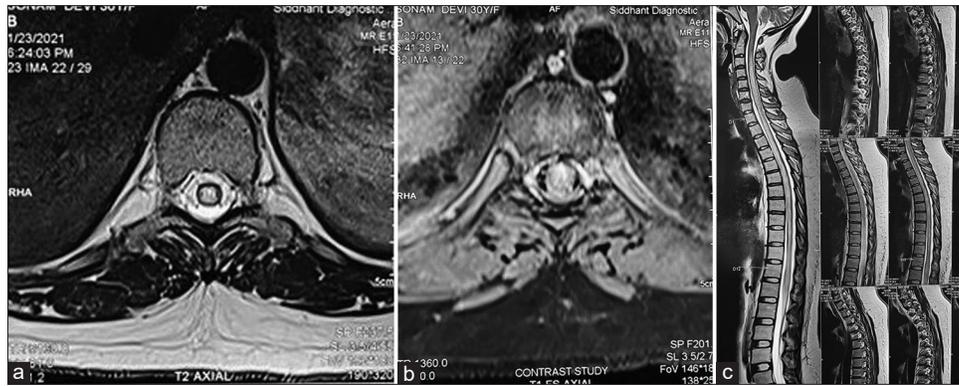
(a-c) MRI whole spine showing long segment cord T2 hyperintensity from C2 vertebral level to conus with ventral subpial enhancement at anterior aspect from D5 to D9
